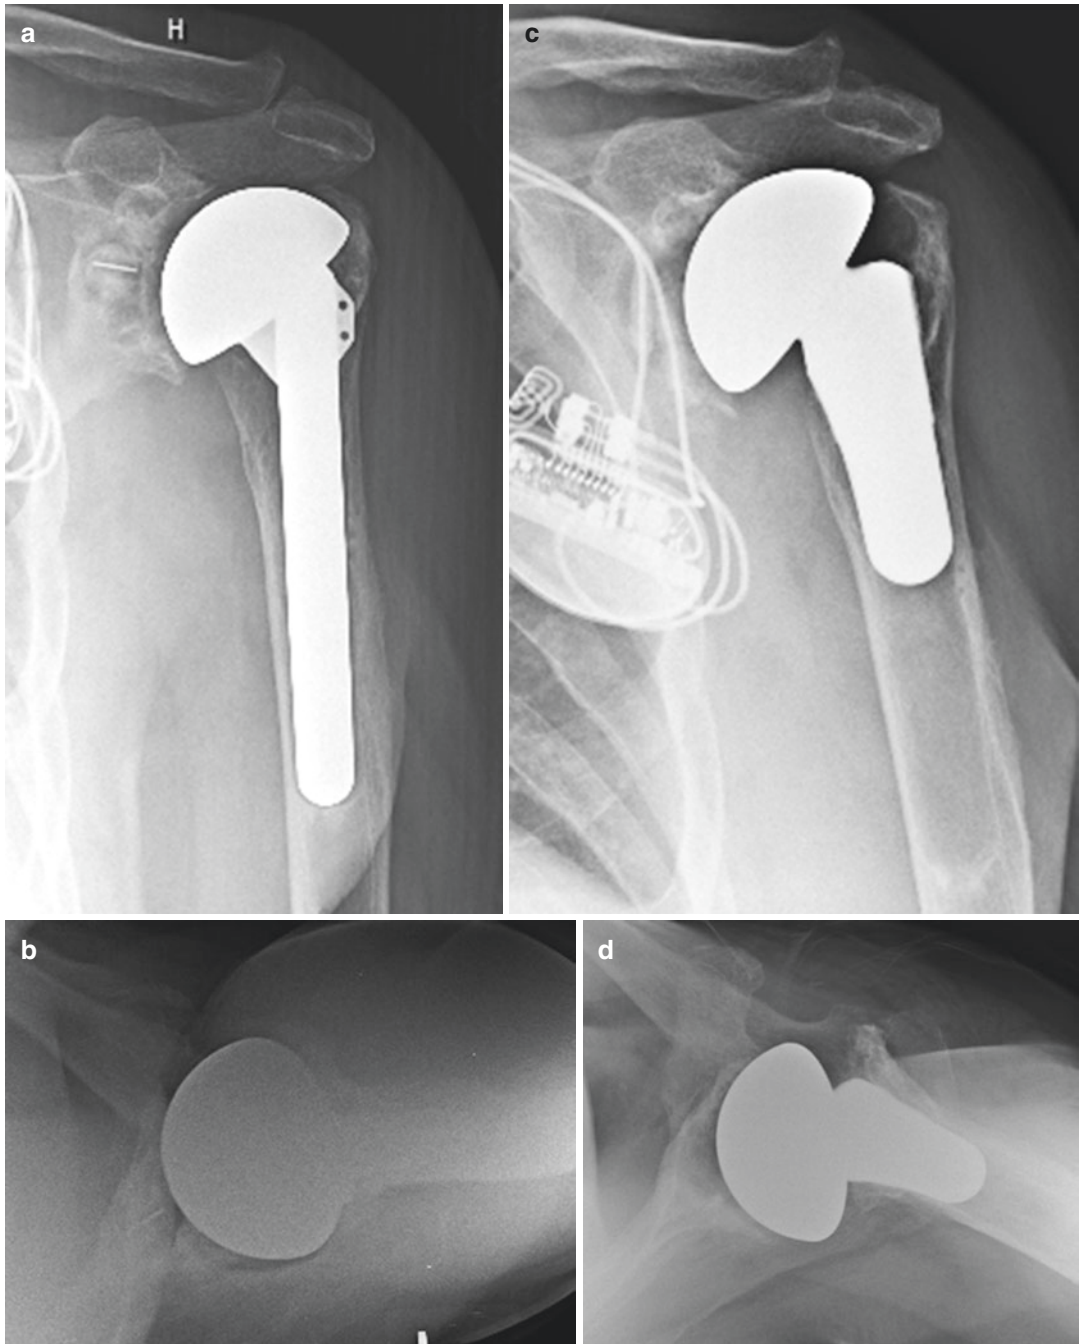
A failed aTSA due to glenoid wear and loosening as seen on AP (a) and lateral (b) radiographs. The patient had an intact rotator cuff and wished to continue
